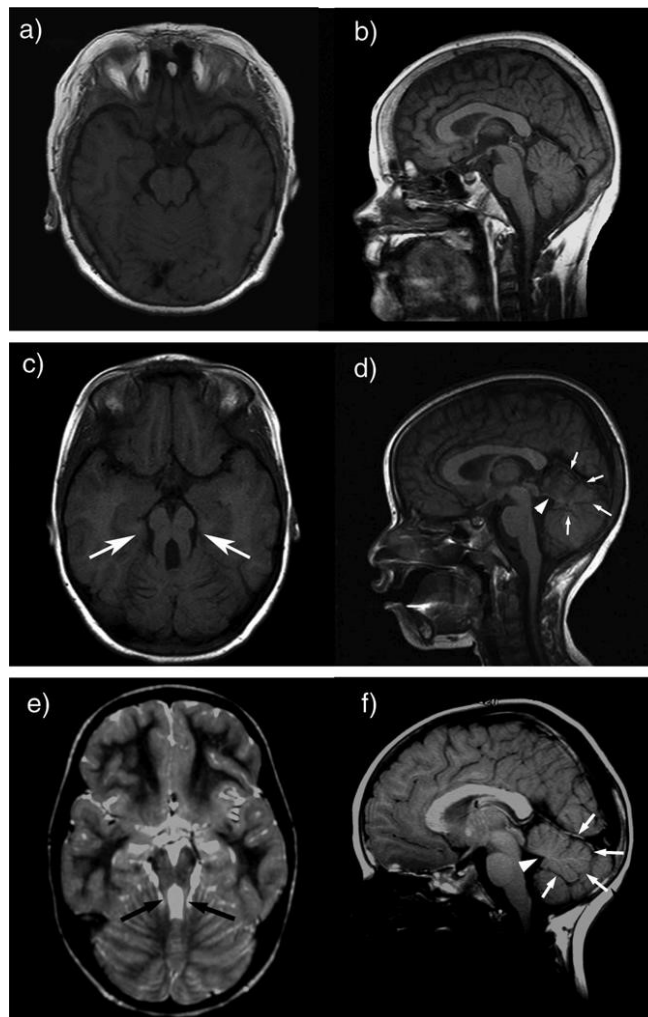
Brain MRI of a healthy individual and two patients with JS. (a) Axial and (b) mid-sagittal plane images show typical appearance of the cerebellar vermis in a normal brain. (c) The MTS (indicated by arrows) and (d) cerebellar vermis hypoplasia (indicated by surrounding four small arrows) and elevated fourth ventricle with abnormal position (indicated by arrowhead) in a patient with JS. (e) The “mild” MTS on sagittal imaging of the other JS patient and (f) mild elevation of the fourth ventricle (indicated by arrowhead) with mild cerebellar vermis hypoplasia (indicated by surrounding small arrows) Adapted from ‘Joubert syndrome (and related disorders)’, by Parisi et al., 2007, *European Journal of Human Genetics*, 15(5), 511-521.
